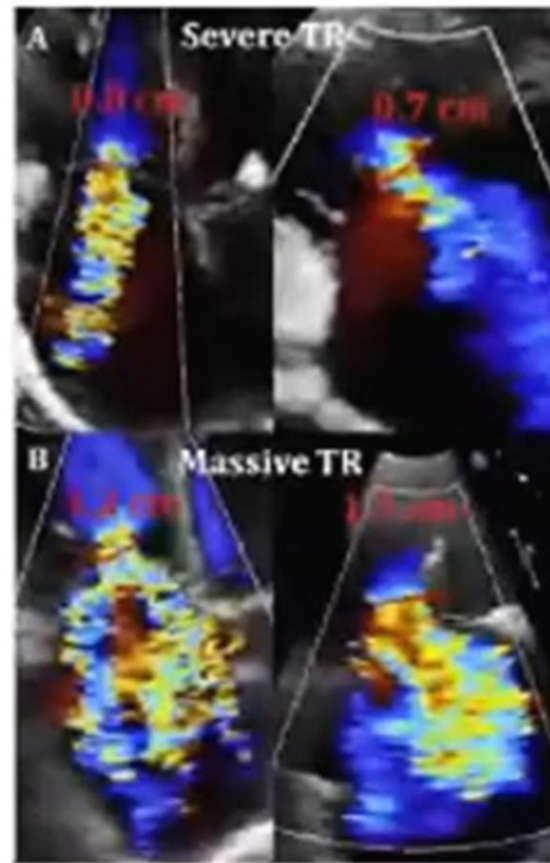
Example of patients in the (A) severe TR (VC average = 0.75 cm) and (B) massive TR (VC = 1.25 cm) groups with color Doppler in the apical four-chamber and RV inflow views.
